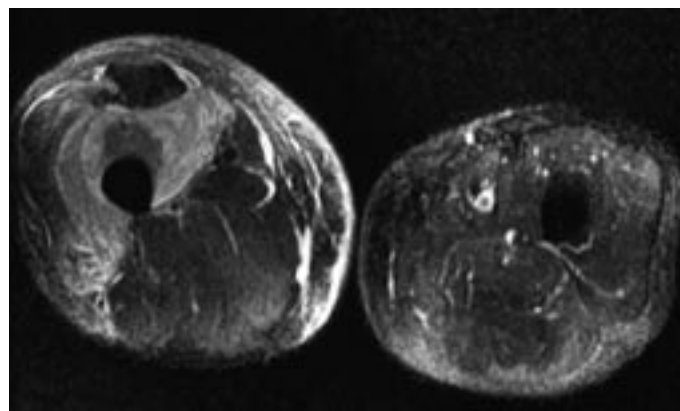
T1-weighted images following gadolinium administration, showing area of non-enhancement in the vastus intermedius muscle adjacent to the periosteum.
